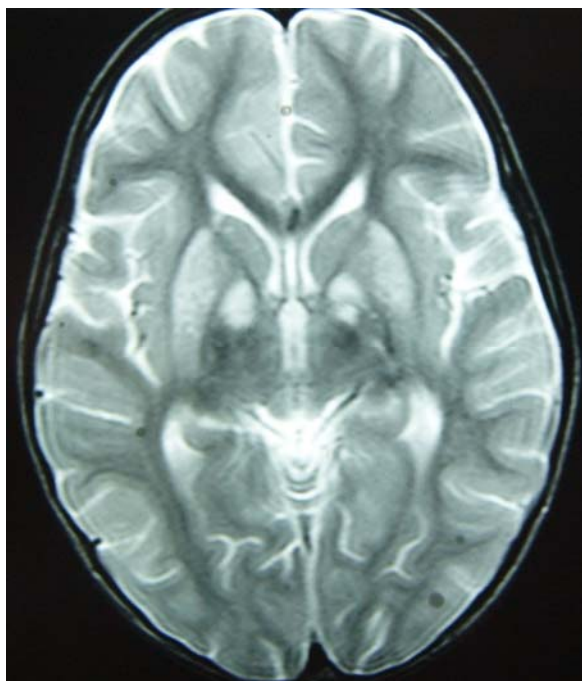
Brain magnetic resonance imaging shows the increased signal intensity in bilateral basal ganglia on T2 sequences
